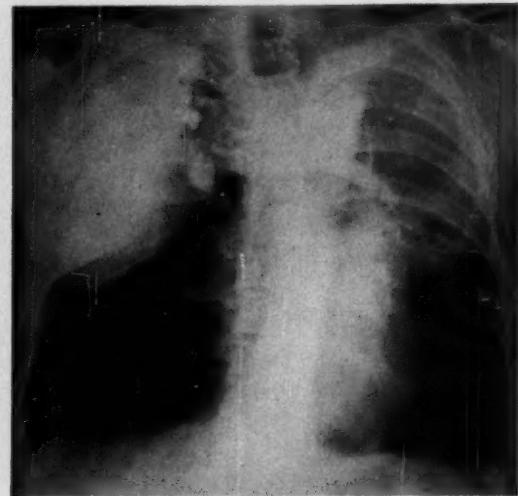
Radiograph showing needle in right pleural space.
